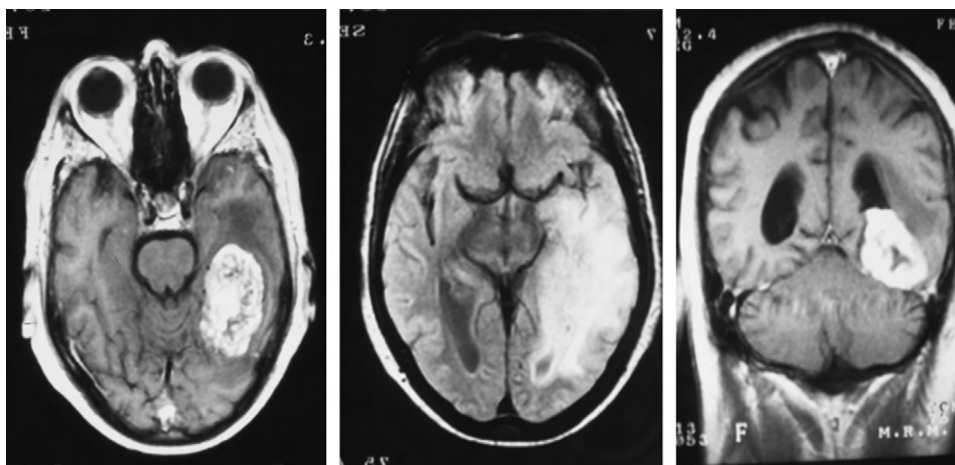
MRI-hyperintense lesion.
